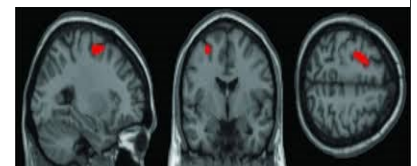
WM CT associated with increased perfusion of left precentral gyrus/frontal middle gyrus/superior frontal gyrus (from Buschkuhl et al. 2014)[1]
